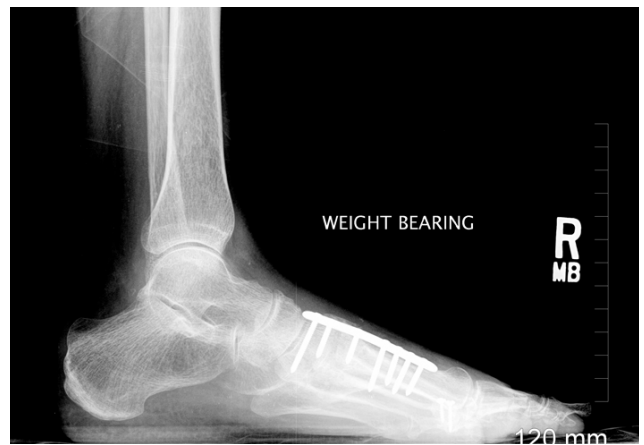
X-ray of the right foot showing fixation of the first tarsometatarsal joint with plates and screws along the first metatarsal and medial cuneiform.
